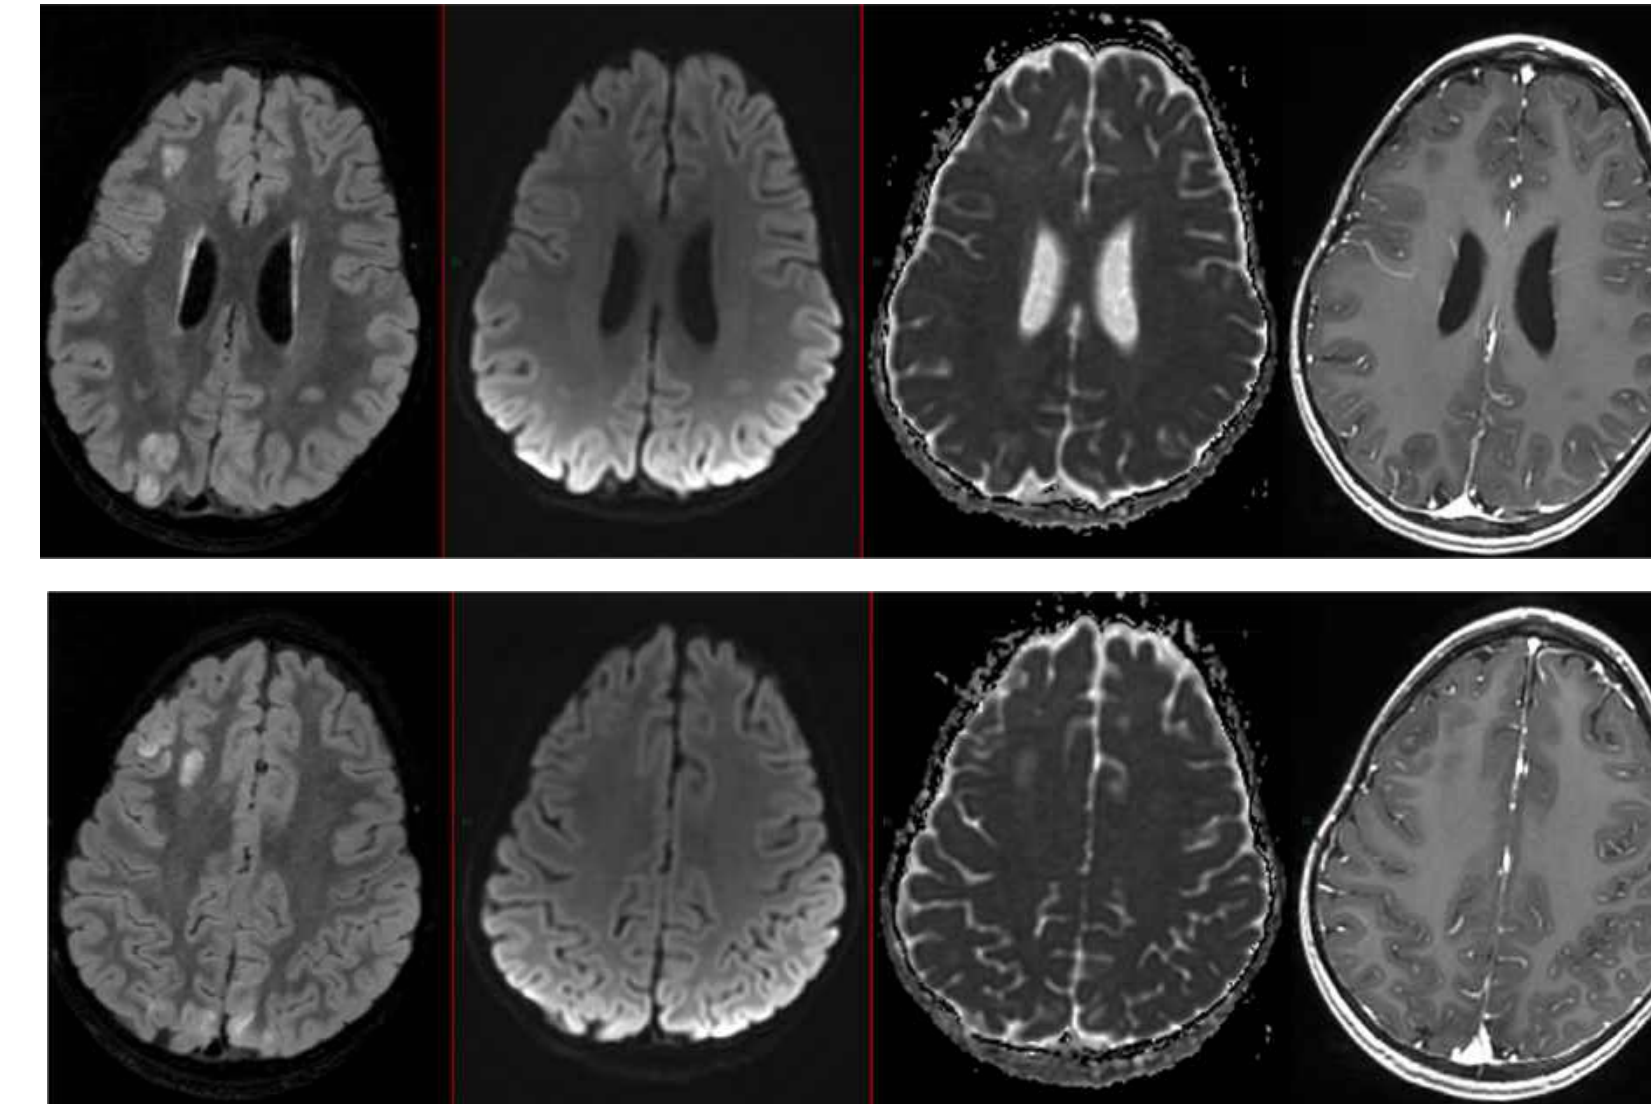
Weighted MRI in FLAIR, DWI, ADC and T1+Gd. Hypertensive lesions on FLAIR in posterior, parieto-occipital and superior frontal subcortical topography, without diffusion restriction or post-gadolinium enhancement.
